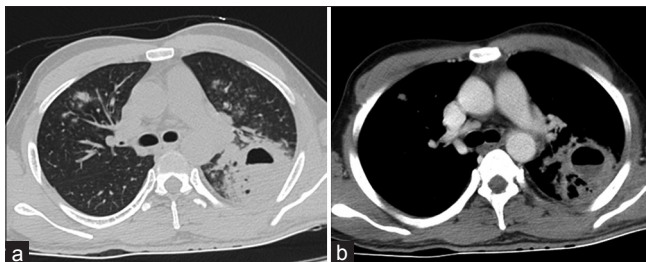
(a) Axial HRCT and (b) corresponding mediastinal window showing cavitary lesion with air fluid level and multiple nodules in a patient with pulmonary tuberculosis
